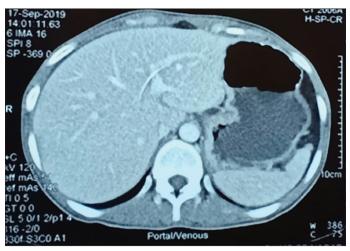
Contrast-enhanced computed tomography showing resolution of intramural gastric gas (Day 9)
